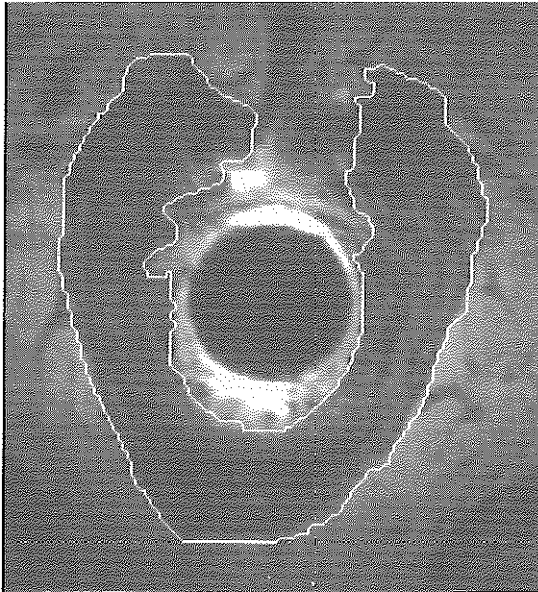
Endoanal magnetic resonance imaging showing delineation of area on the image. Area is calculated by the integral software.
